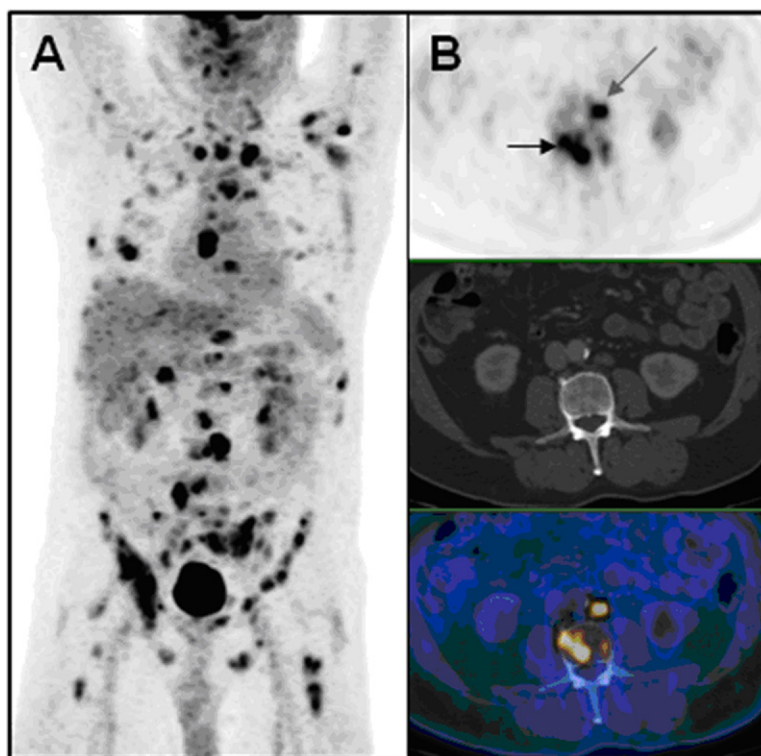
(A) Generalized BM detected by FDG-PET/CT (MIP-Image) from a high-risk prostate cancer patient. (B) Transaxial images from a metastatic bone lesion (black arrow) and a malignant lymph node (gray arrow).
